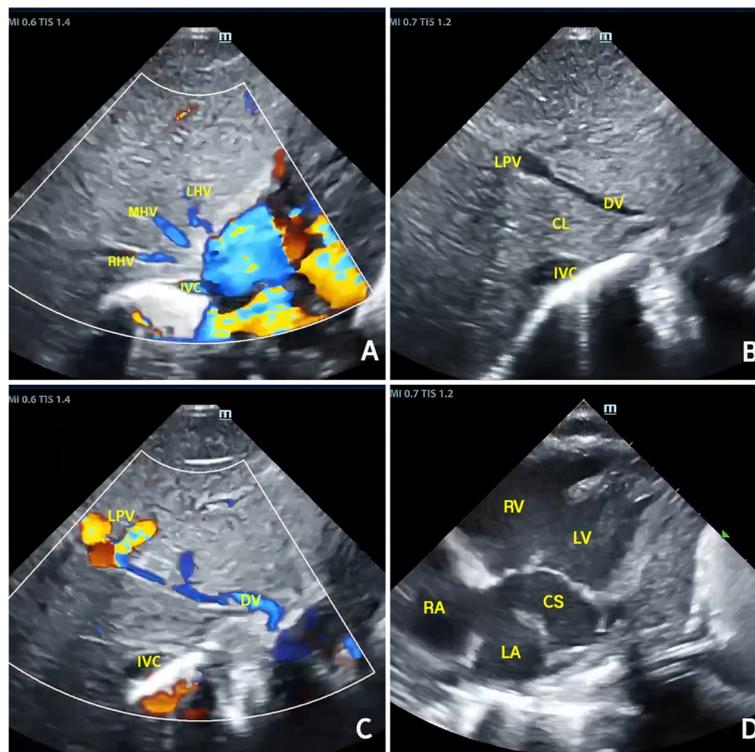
Ductus Venosus Draining into the Coronary Sinus on Postnatal Day 3 Ultrasound. (4A) Color Doppler Flow Imaging at the First Hepatic Portal in a Neonate. (4B) Two-dimensional Ultrasound Demonstrating a Non-occluded DV. (4C) CDFI Showing the Course of the DV Without Drainage into the IVC. (4D) Subxiphoid Non-standard Four-chamber Heart View: Depicting Drainage into a Dilated CS. LPV: Left Portal Vein; CL: Caudate Lobe; DV: Ductus Venosus; LHV: Left Hepatic Vein; MHV: Middle Hepatic Vein; RHV: Right Hepatic Vein; IVC: Inferior Vena Cava; LA: Left Atrium; LV: Left Ventricle; RA: Right Atrium; RV: Right Ventricle
